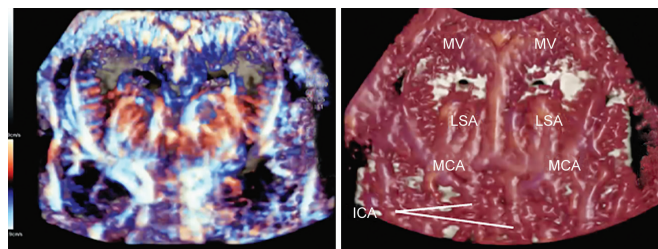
Normal intracranial sonoangiogram at 19 weeks by HDlive flow imaging. Brain vascular networking is well created as early as 19 weeks: Left: Bidirectional power Doppler HDlive flow image of brain vasculature, and Right: Monocolor demonstration; (MCA: middle cerebral artery; ICA: internal carotid artery; LSA: lenticulostriate arteries; MV: medullary veins)
